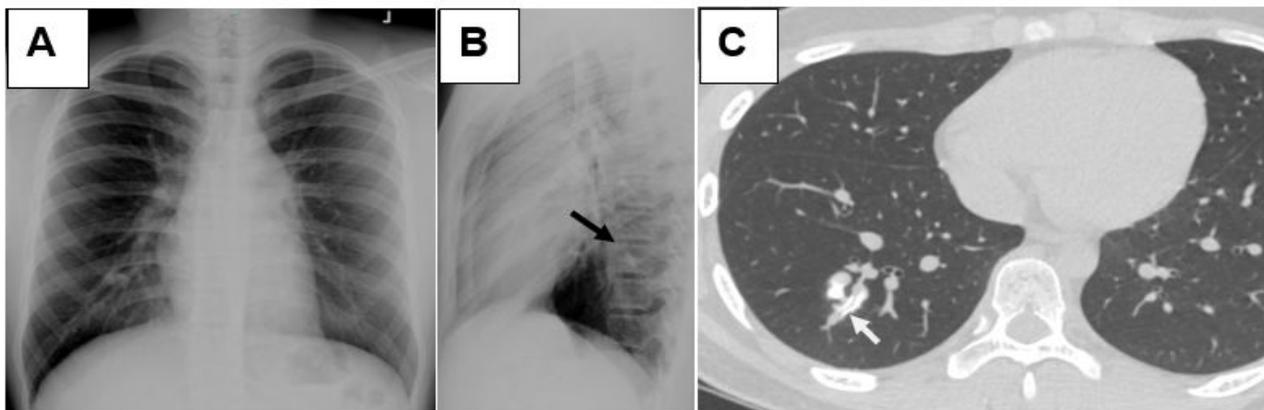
Chest radiograph of a 16-year-old boy with osteosarcoma at the right femur. At first there was no nodule detected on the PA radiograph (A) but the lateral radiograph; (B) helped detect a nodule overlying the spine (black arrow); and (C) Chest CT images showing endobronchial metastases at the lateral basal segment of RLL (white arrow). Tissue diagnosis from wedge resection confirmed pulmonary metastasis from osteosarcoma.
